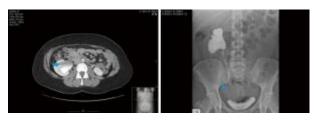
Computed tomography scan of the kidneys-ureter-bladder (CT KUB) demonstrating right sided hydronephrosis (arrow). Intravenous urogram (IVU) showing narrowing of the right distal ureter (arrowhead). Reproduced from [57] Under the Creative Commons Attribution License.
